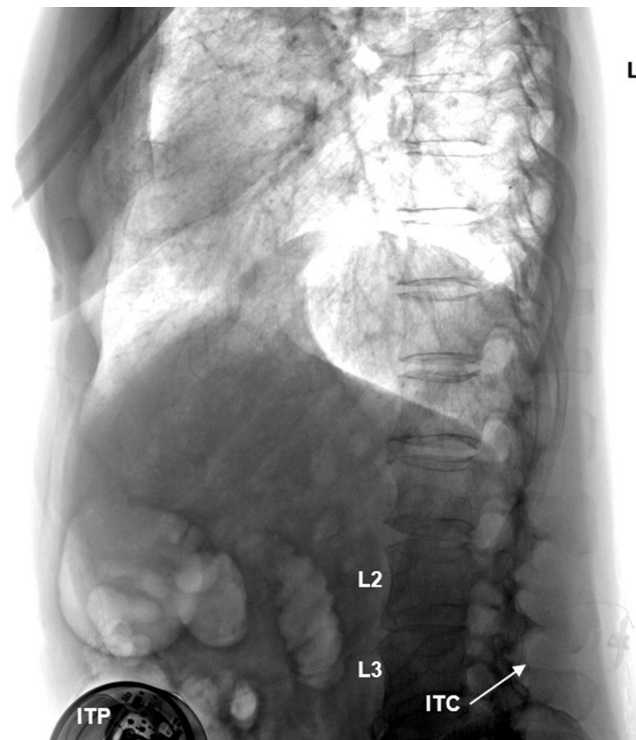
Lateral view of lumbar spine X-ray showing location of ITP with the radiopaque ITC entering the intrathecal space at L2–L3. Arrow indicates the site of ITC entry into the intrathecal space.
